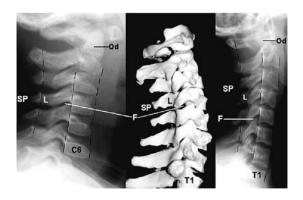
B.2 X-ray of the lateral cervical spine, showing three of the lines that are indicated in Figure 7.3.B.1. Od, odontoid; F, facet joint; L, lamina; SP, spinous process spaces.
